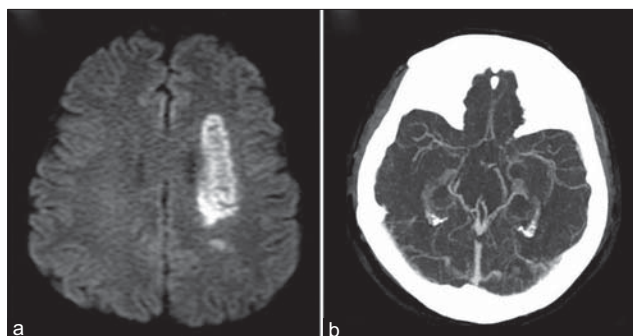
(a) Axial brain diffuse-weighted image magnetic resonance imaging. (b) Computed tomography angiography
